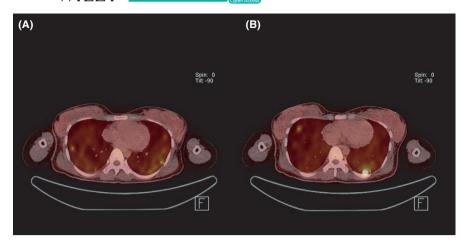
PET/CT scan showed multiple nodular lesions in both lungs with varying FDG uptake (A) with highest uptake appeared in a nodule in left lower lobe (B)
